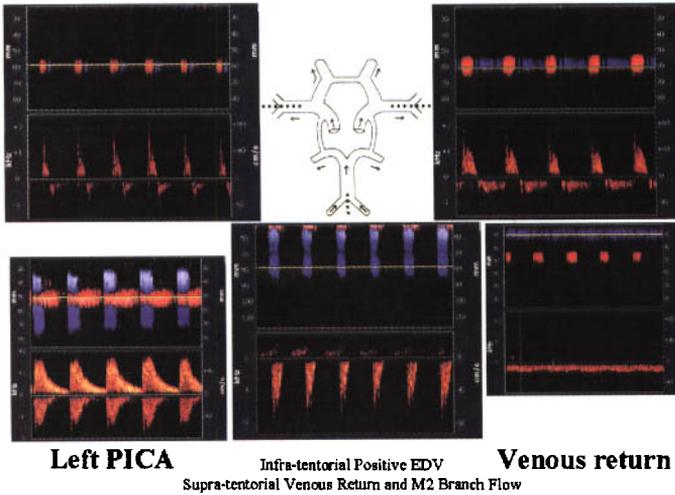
Spectral transcranial Doppler (TCD) and M-mode findings showing residual flow to the posterior inferior cerebellar artery (bottom left image insert), and positive venous return due to antegrade flow in an early M2 MCA branch (M-mode, bottom right image). These findings help explain a discrepancy between nuclear cerebral blood flow test and initial TCD examination.
